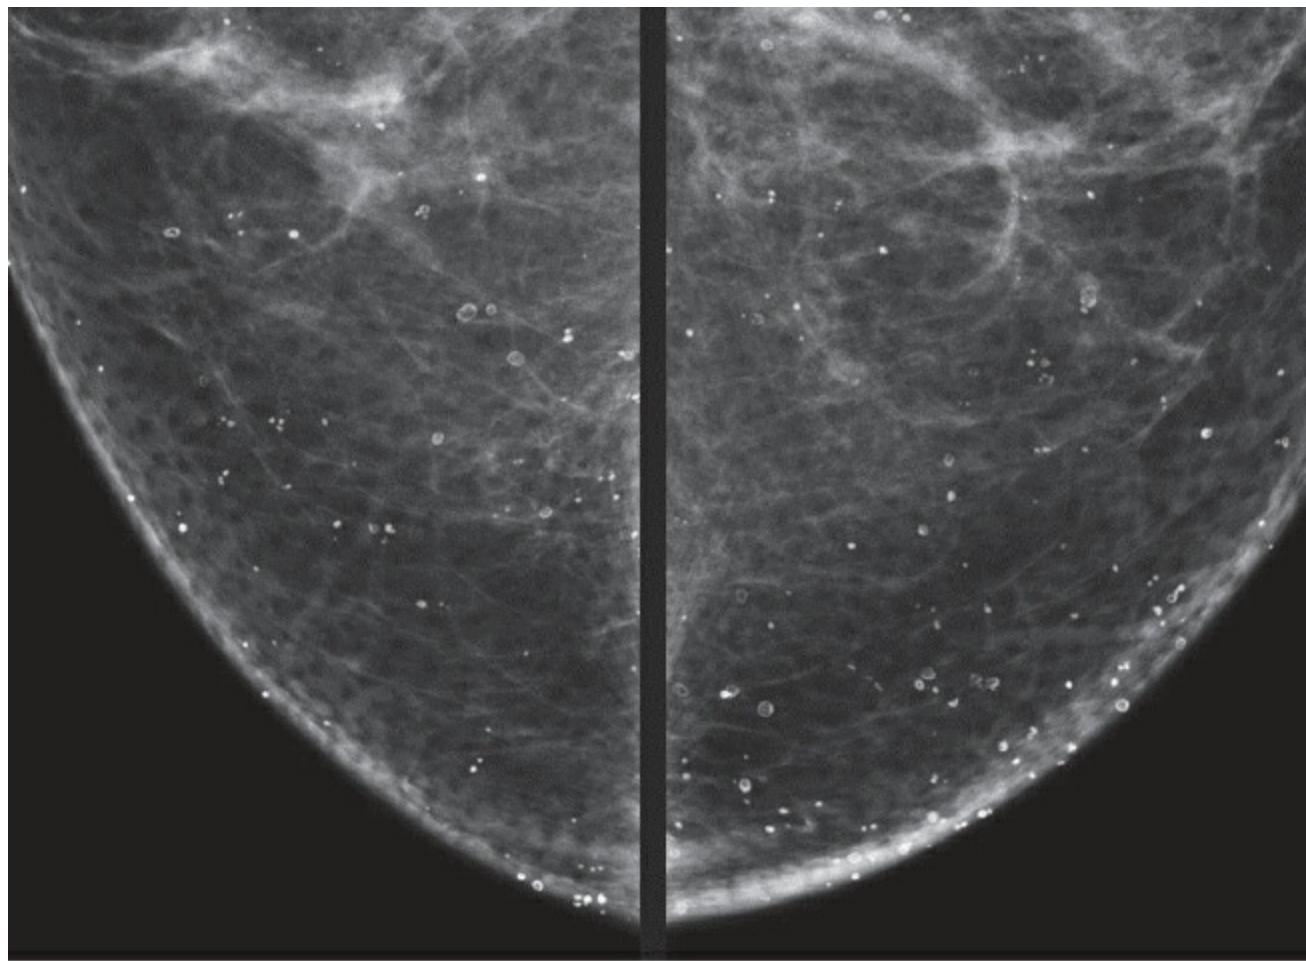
TYPICALLY BENIGN: SKIN. SKIN calcifications in parasternal location on paired craniocaudal views. Note that some calcifications display typical radiolucent centers, whereas others that are projected tangentially are seen to be located within the skin.
